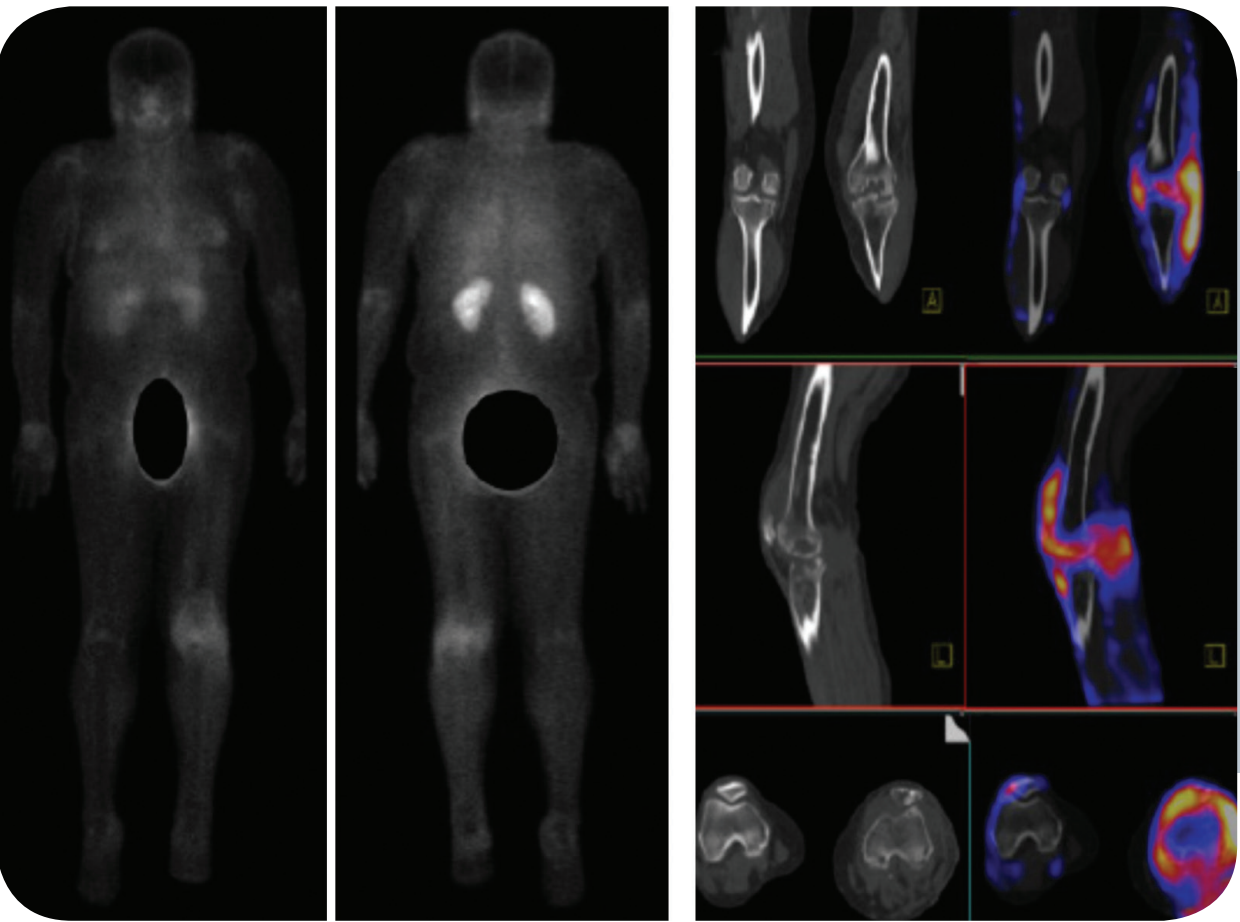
(A) whole body scan showing normal biodistribution and elimination route of <sup>99m</sup>Tc-UBI [29-41], with abnormal focal uptake in the left knee. (B) SPECT / CT shows that the uptake of the radio-tracer includes bone and soft tissue at this level; with anatomical changes that are characterized by lytic destruction of the facet joint of the femur, tibia and patella, loss of muscle planes and striation of the fat, consistent with chronic osteomyelitis (INCan, 2013).
